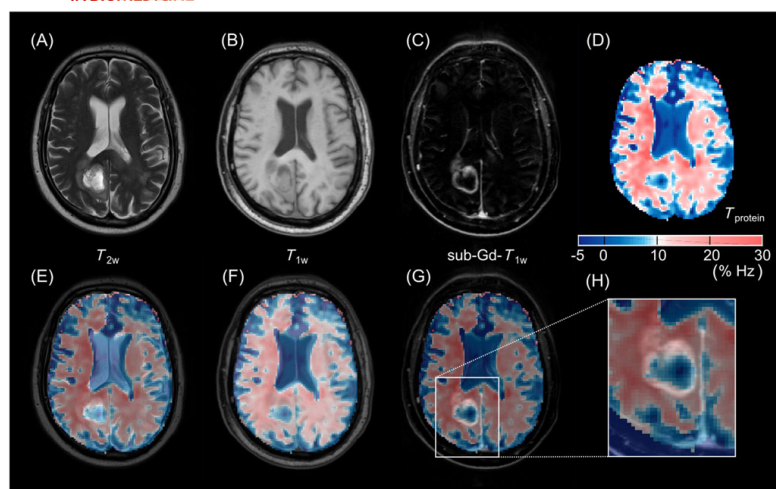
In vivo* dualCEST examination at $B_0 = 3$ T. Multi-modal MR images of a patient with glioblastoma. (A–C) Conventional MR contrasts: T_2 -weighted (T_{2w}), T_1 -weighted (T_{1w}) and subtracted gadolinium contrast-enhanced T_1 -weighted (sub-Gd- T_{1w}) MR images. (D) The selective dualCEST signal of mobile proteins T_{protein} , showing substantial alterations of the mobile fraction of the proteome in the tumor region. (E–H) Fusion of conventional MR contrasts and the dualCEST image
